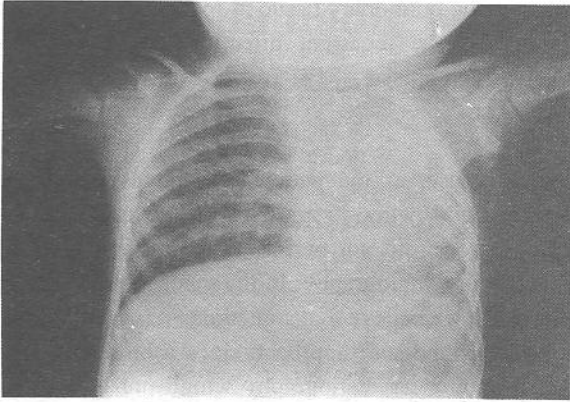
The chest x-ray of the patient showing the shift of the heart and mediastinum to the left. The left hemithorax is smaller than the right with the crowding of the upper chest.
